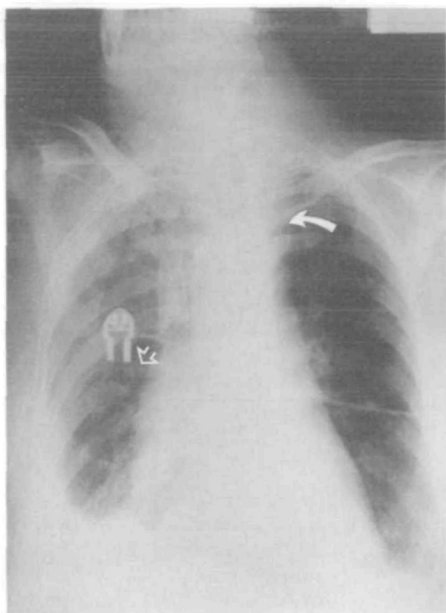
Chest radiograph showing the tip of the dual-lumen catheter (open arrow) in the pleural cavity.
